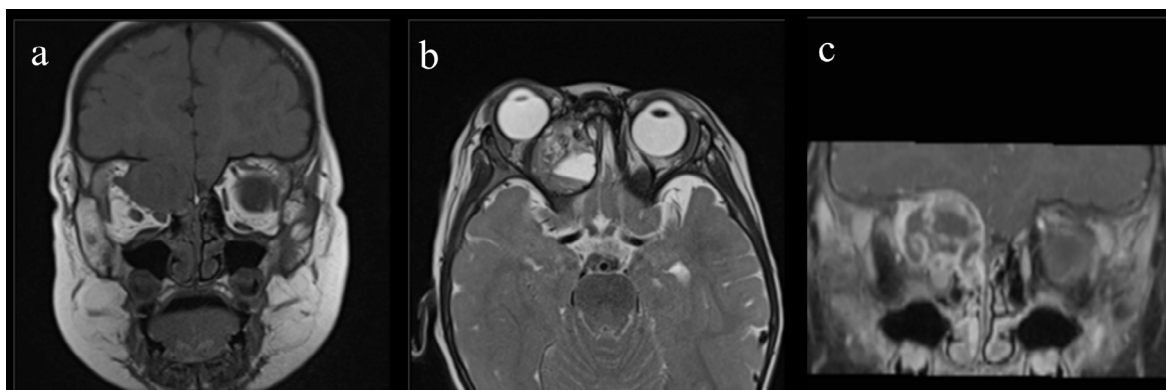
Initial Orbit magnetic resonance images. Initial orbital MRI revealed a well-defined mass of about 30×26 mm from the right ethmoid sinus to the right orbit. The right eyeball was protruding and excluded due to the exclusion due to the tumor. a) Coronal T1-weighted MRI showed that the tumor showed a faint hyperintensity mass shadow compared to muscle. b) Axial T2-weighted MRI showed mild high-intensity to high-intensity mass shadows, and cyst formation was observed in a part of the area. c) Coronal contrast-enhanced T1 MRI showed that the tumor extended to the anterior skull base and had a contrast-enhanced effect along the dura mater.
